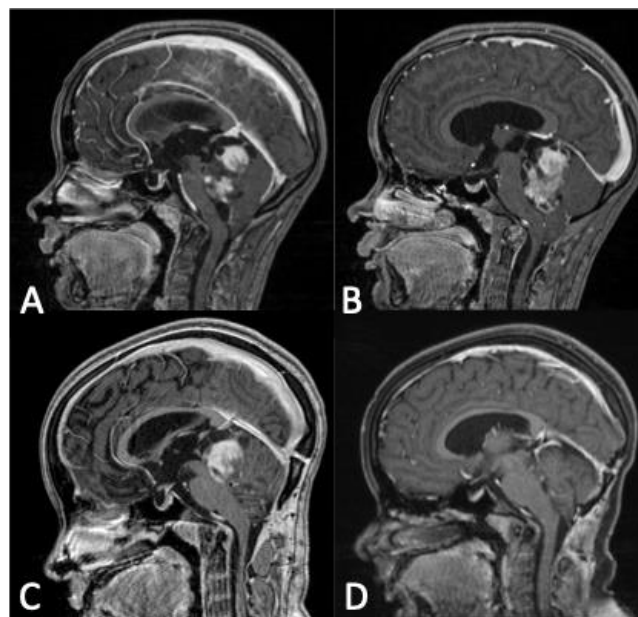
Sagittal contrast-enhanced MRI. A e B) Preoperative. C) Residual tumor after telovelar resection. D) Complete extraction after combination with supracerebellar infratentorial approach.
